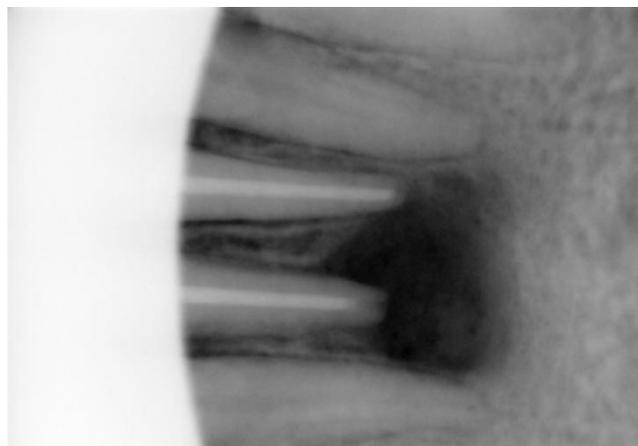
Photograph showing radiographic features of periapical inflammation
